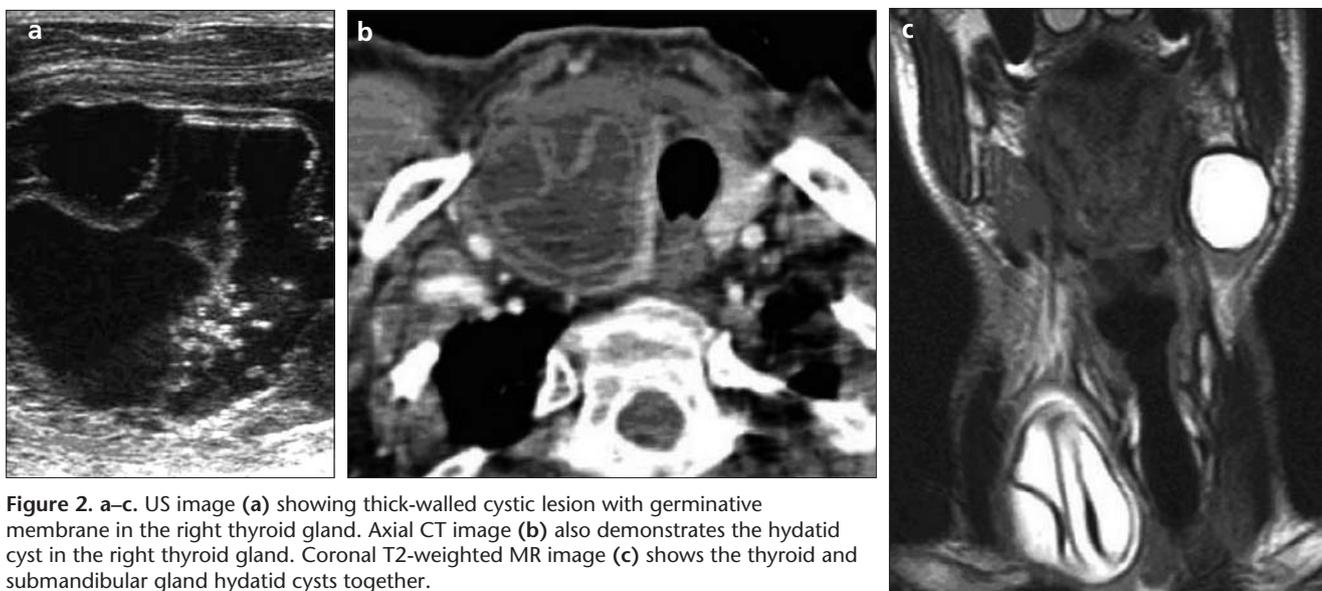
a–c. US image (a) showing thick-walled cystic lesion with germinative membrane in the right thyroid gland. Axial CT image (b) also demonstrates the hydatid cyst in the right thyroid gland. Coronal T2-weighted MR image (c) shows the thyroid and submandibular gland hydatid cysts together.
